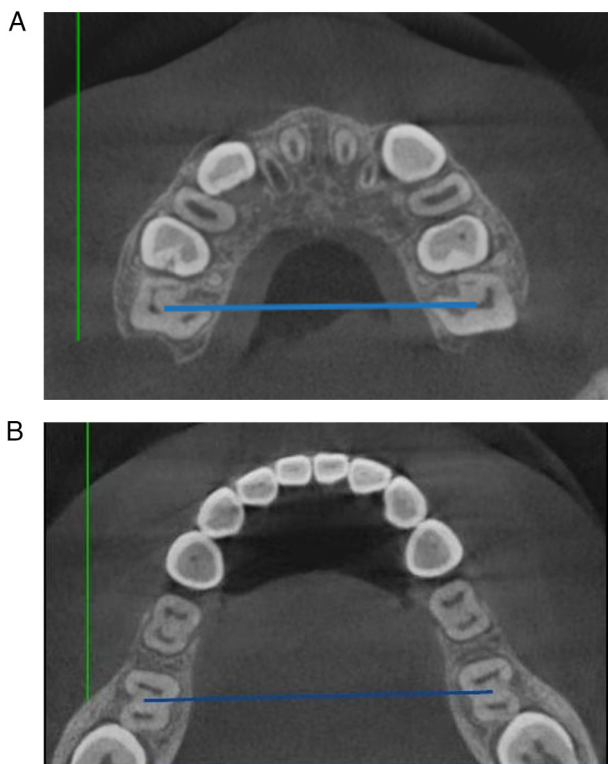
(A) Example of the pre-treatment CBCT measurement of the width of maxillary basal bone arches; (B) Pre-treatment CBCT measurement of the width of mandibular basal bone arches. CBCT, cone beam computed tomography.
